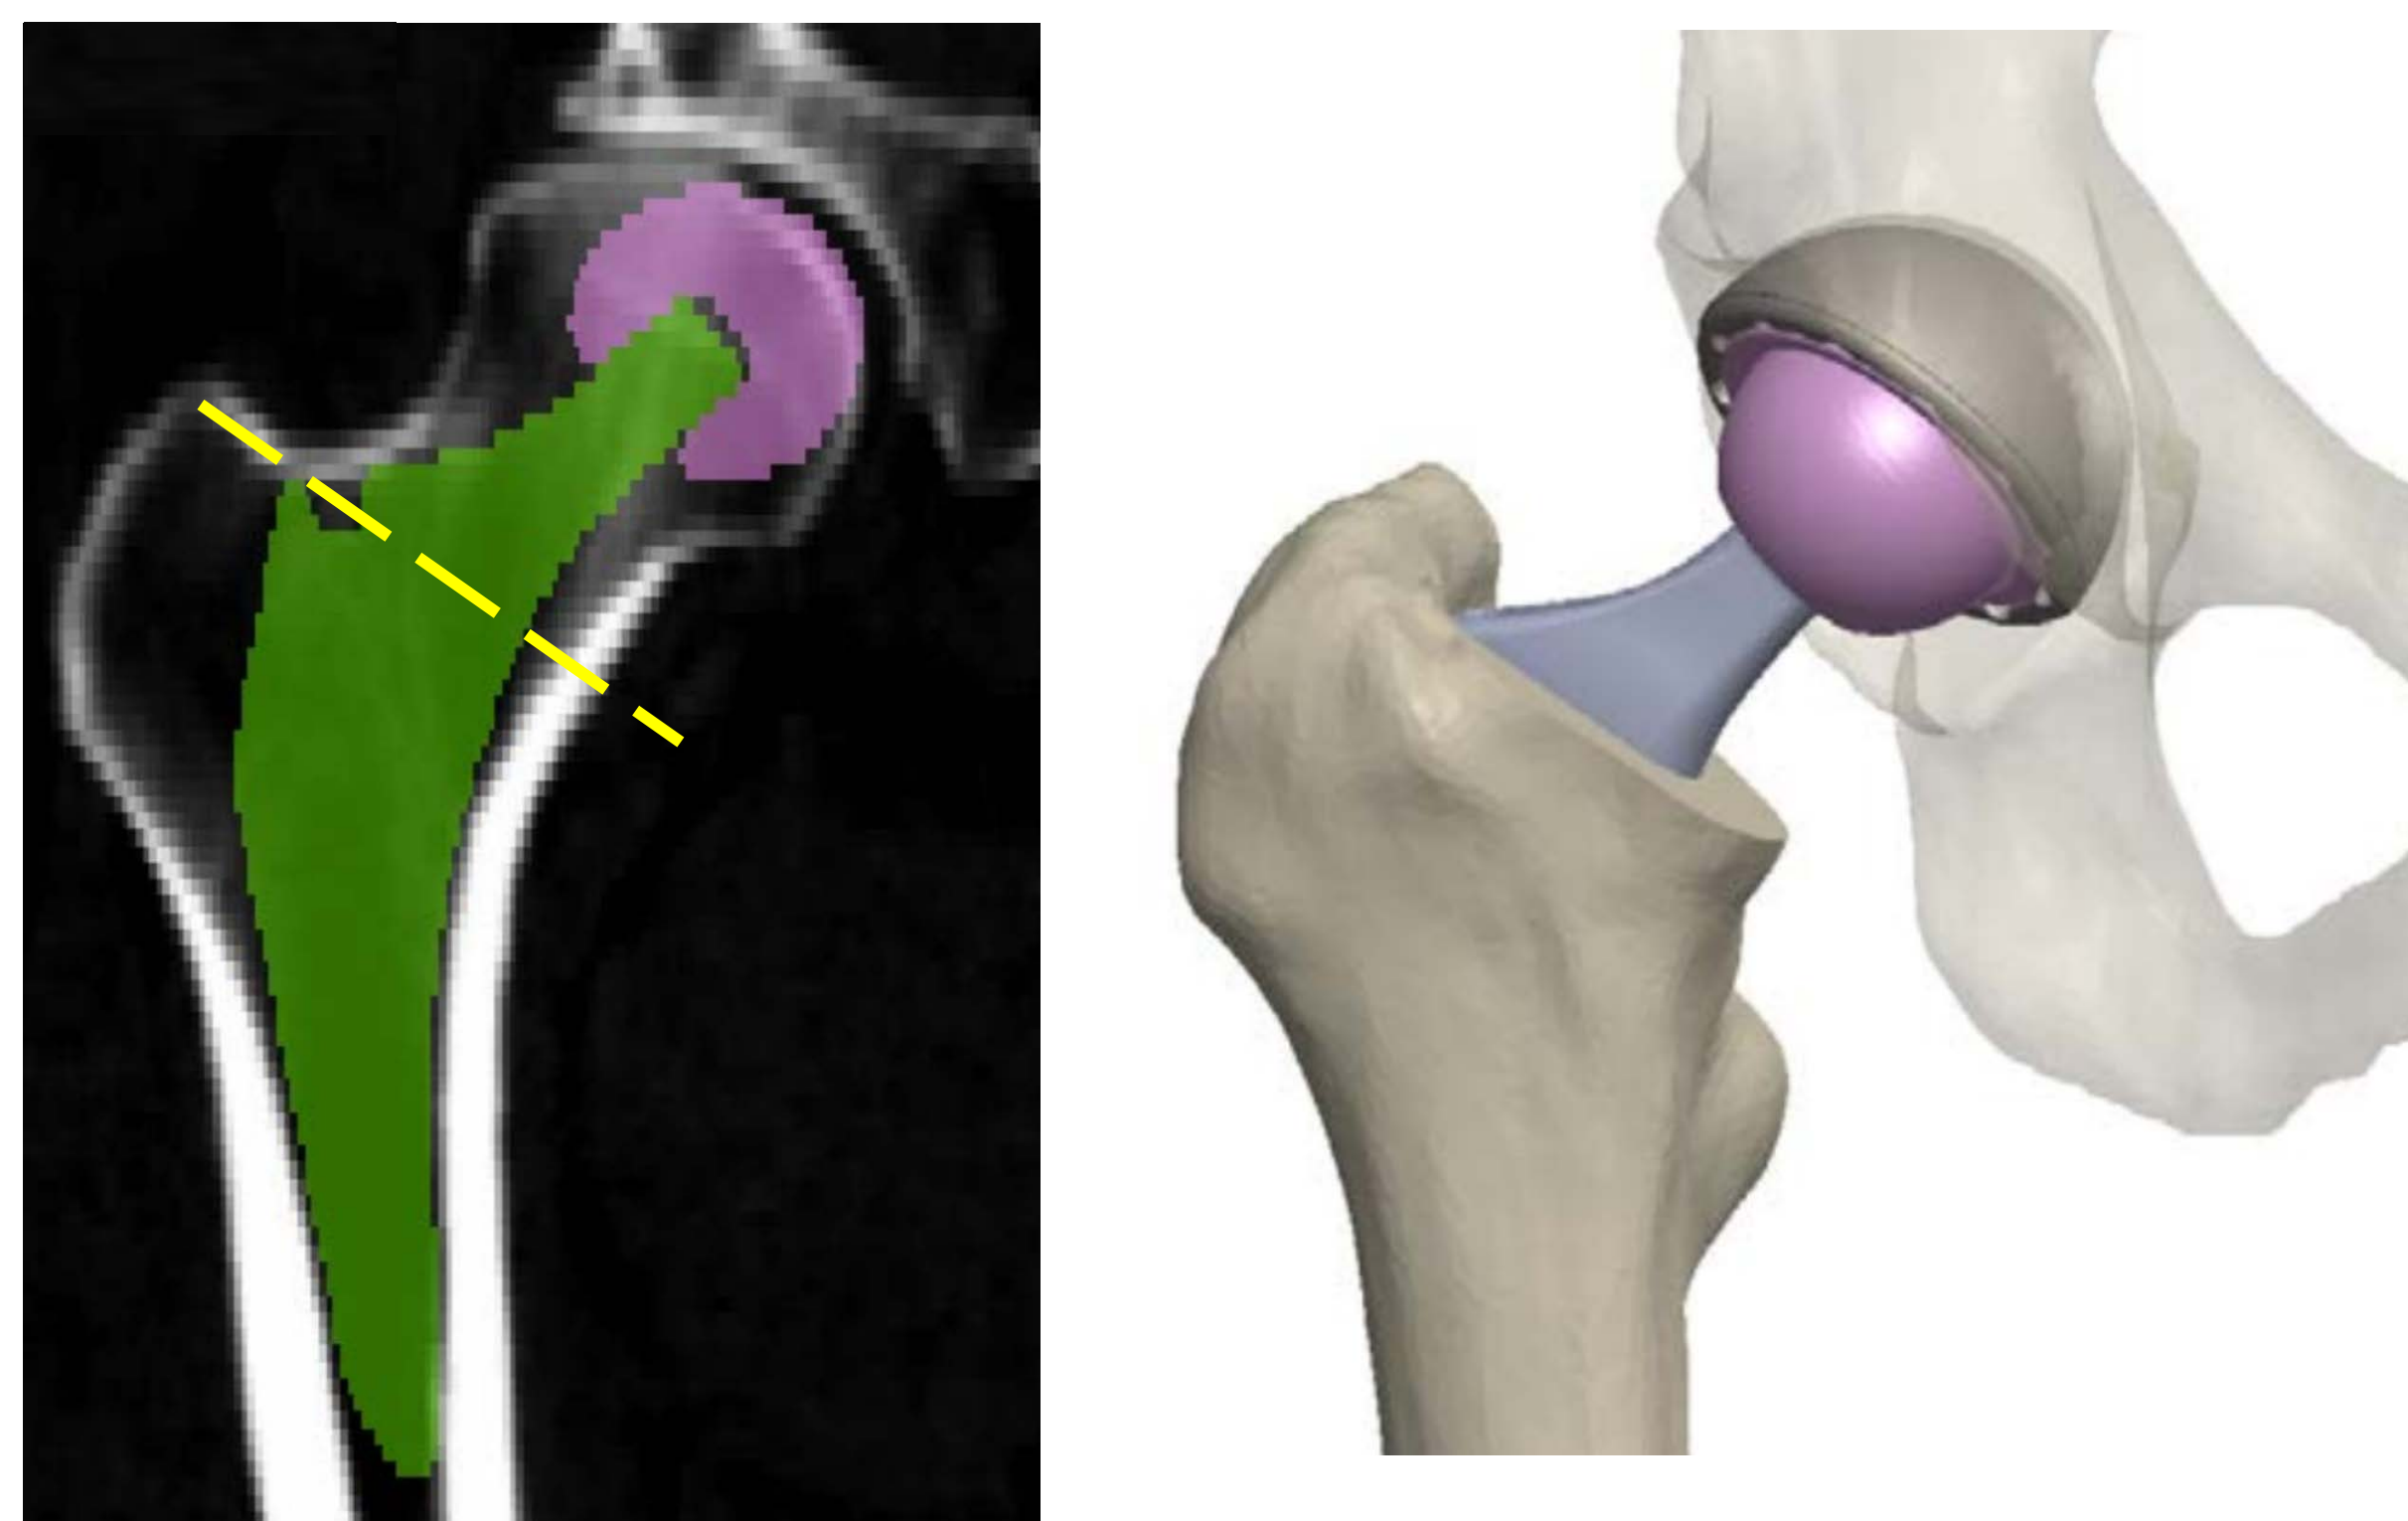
3D templating from CT to determine a planned osteotomy.
